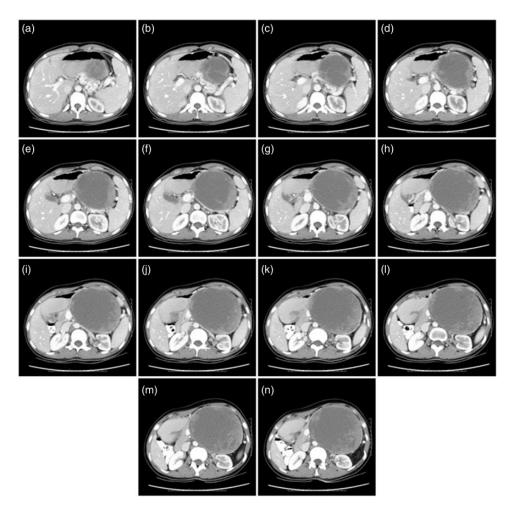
Preoperative enhanced computed tomography scan showed splenic varices and splenomegaly. A varicose vein plexus was present on the upper edge of the pancreatic body and posterior gastric wall.
